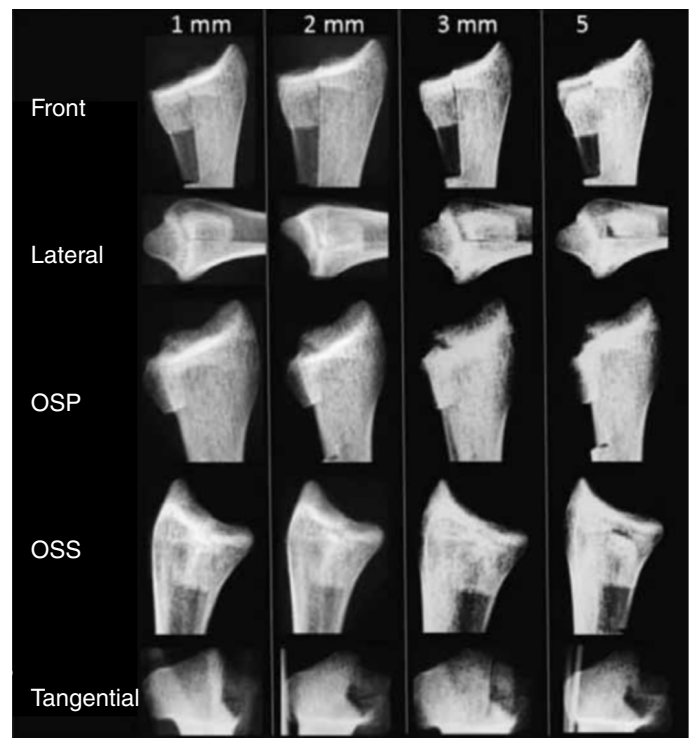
Radiographs with joint steps of 1, 2, 3 and 5 mm in the front, lateral, OSP, OSS and tangential views.
